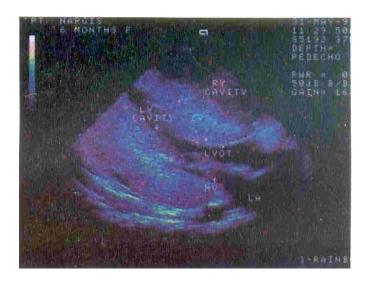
Long axis par asternal view of echocardiographic examina tion showing diffusely thickened interventricu lar septum (IVS) and narrow (slit like) left ventricu lar cavity and left ventricu lar outfolow tract (LVOT).
